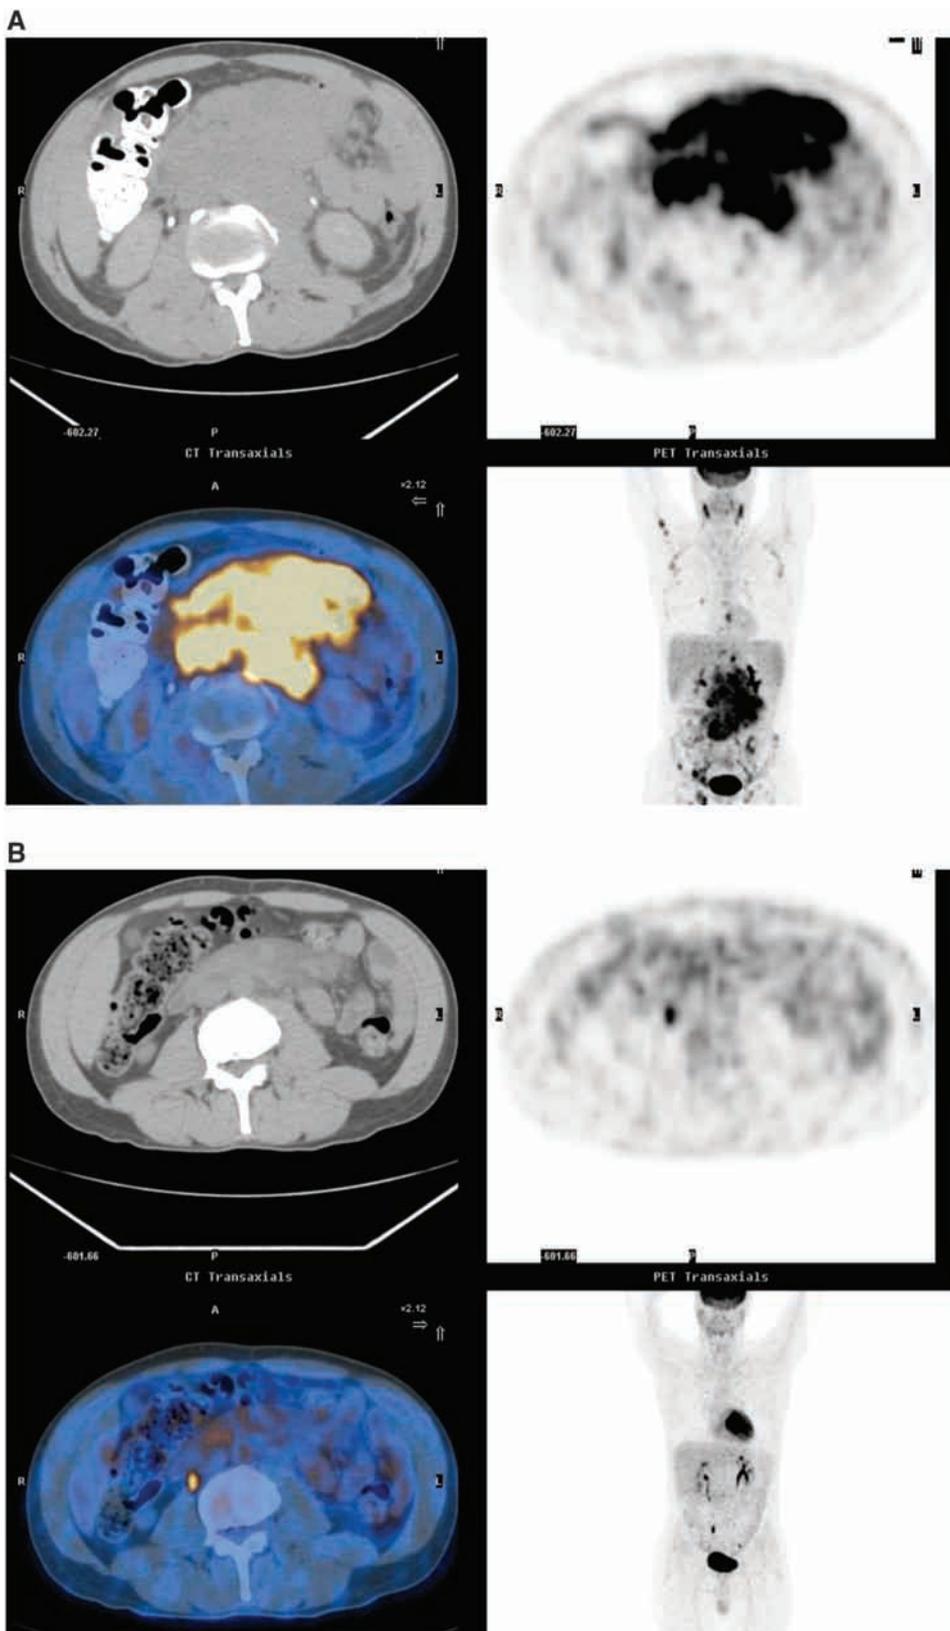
Pre- (A) and post-therapy (B) PET/CT in a lymphoma patient expected to have a good outcome.
